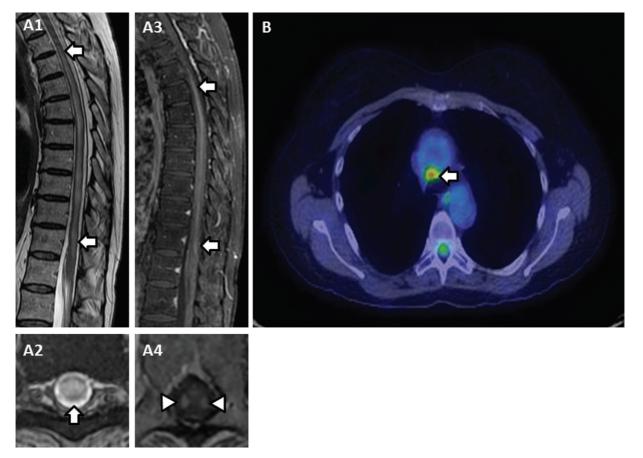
MRI features of paraneoplastic myelopathy. Sagittal T2-weighted thoracic spine MRI showing a longitudinally extensive T2-hyperintense lesion (A1, arrows) involving the central cord on axial T2-weighted images (A2, arrow). Sagittal (A3) and axial (A4) T1-weighted post-gadolinium sequences show a tract-specific enhancement involving the lateral columns (A3, arrows; A4, arrowheads). (B) 18F-Fluoro-deoxyglucose positron emission tomography showing a hypermetabolic (red color) precarinal lymph node (B, arrow).
